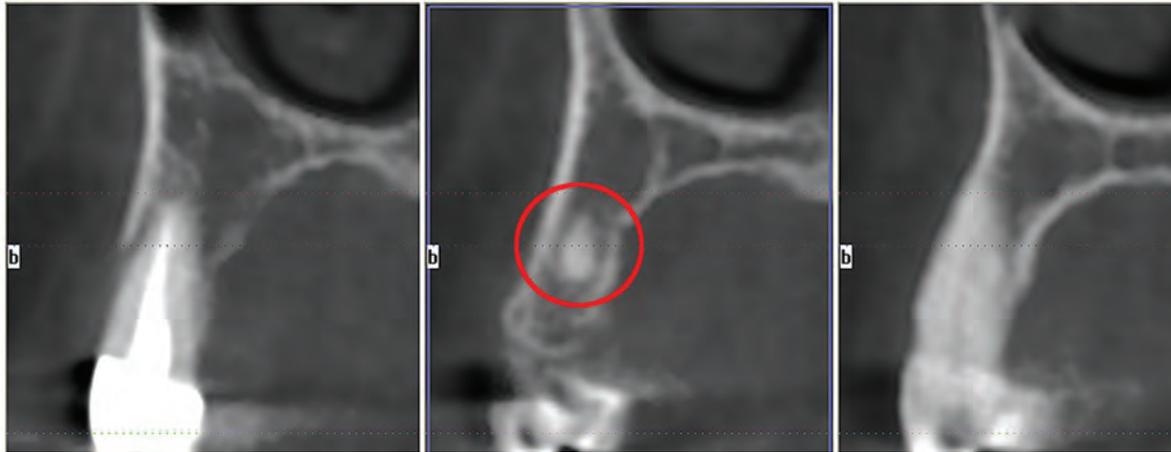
Cross-sectional CBCT slices showing retained root tip from previously extracted tooth No. 5, along with adjacent teeth. Note the lack of bone on the buccal of tooth No. 4
